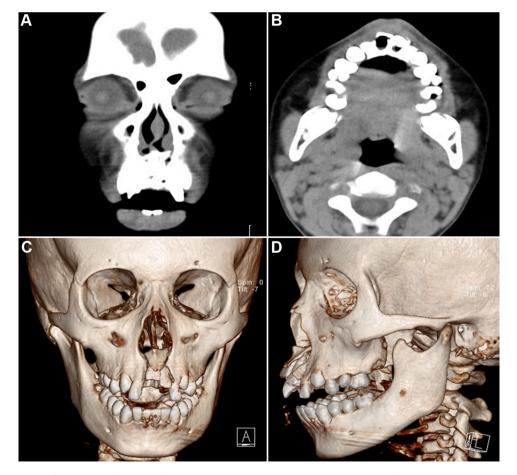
Computed tomography (CT) images. (A) Coronal image. (B) Axial image. (C and D) 3D-CT images.
